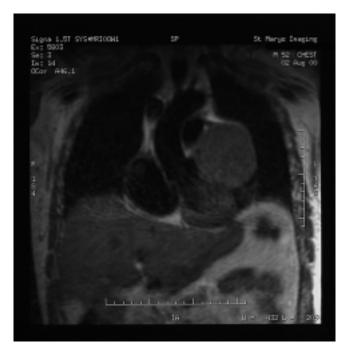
MRI scan demonstrating the haemangioma.
